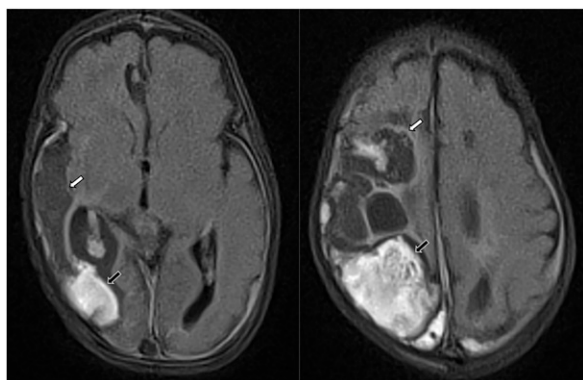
Magnetic resonance imaging of the brain (T1-weighted axial sections) on day 44 after birth showing extensive areas of cystic encephalomalacia (white arrows) and residual products of parenchymal hemorrhages (black arrows), predominantly affecting the right parieto-occipital lobe.
